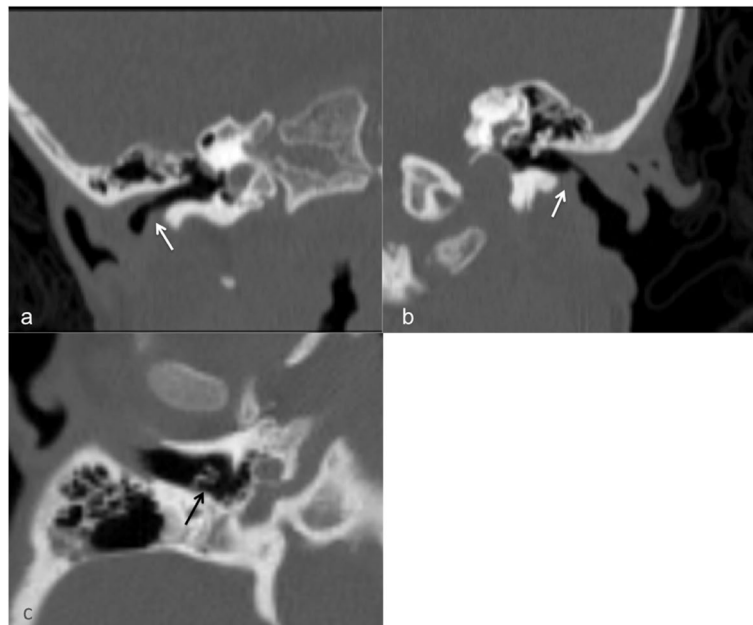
Coronal oblique reformatted CT image reveals narrowing of right (a) and left (b) EAC (white arrows). Tympanostomy tube (black arrow) on right tympanic membrane is seen on axial CT image
